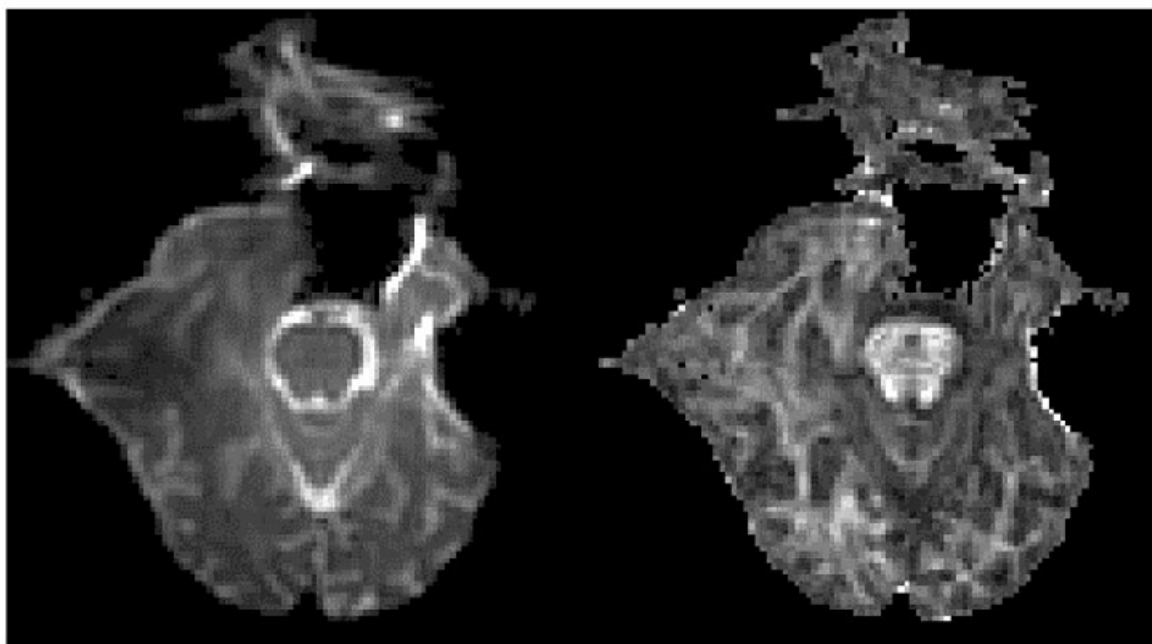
Susceptibility artifacts in DT-MRI images acquired at 3 T with single-shot EPI. The phase encode direction is left–right. (a) T_2 -weighted image intensity. (b) Fractional anisotropy map
